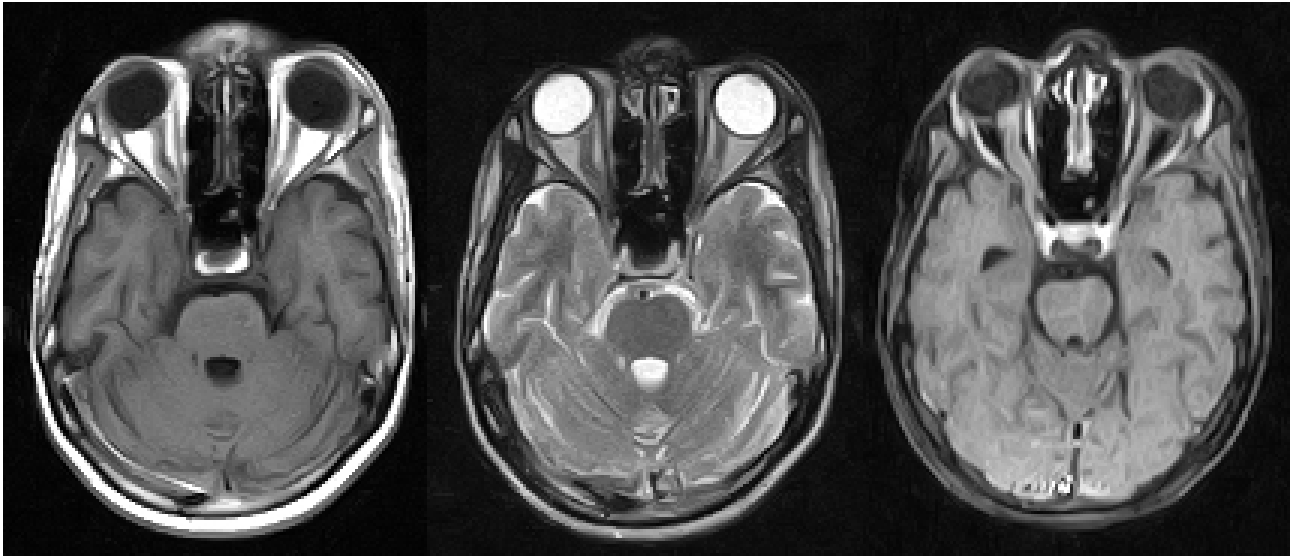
(a) T1w MRI image showing hypointense both optic nerves with thickened and tortuous right optic nerve. (b) T2w MRI image showing hyperintense optic nerves more on right side as compared to left side suggestive of edematous changes. (c) Post contrast fat suppressed T1w showing moderate to intense enhancement of bilateral optic nerves more on right side
